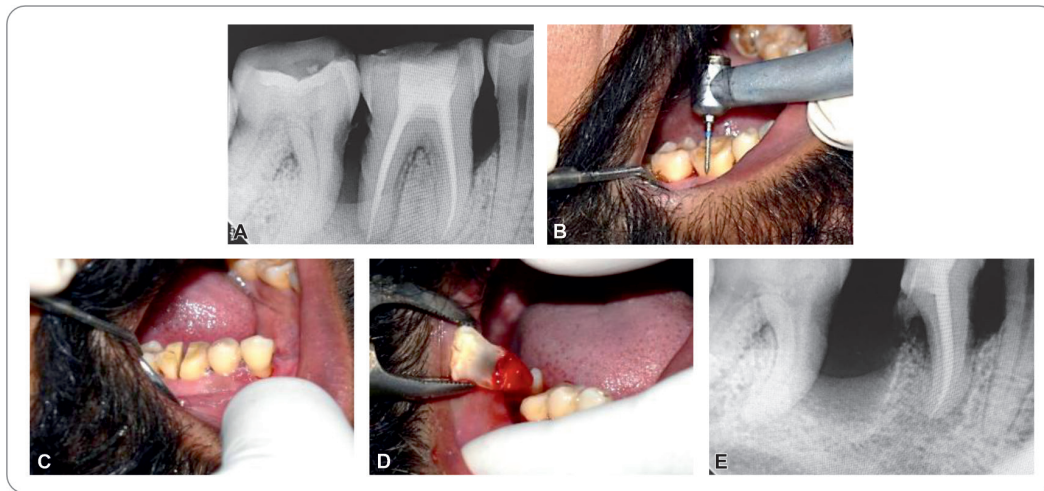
Clinical steps for performing hemisection. Diag. A: Preoperative radiograph after endodontic treatment; Diags B and C: Tooth is cut into two mesial and distal pieces; Diag. D: Distal fragment is extracted and Diag. E: Postoperative radiograph.
